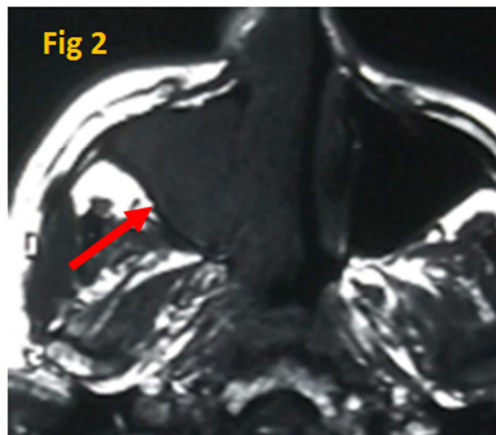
A brain magnetic resonance imaging showed a nasal and maxillary tumor with hyposignal T1.
